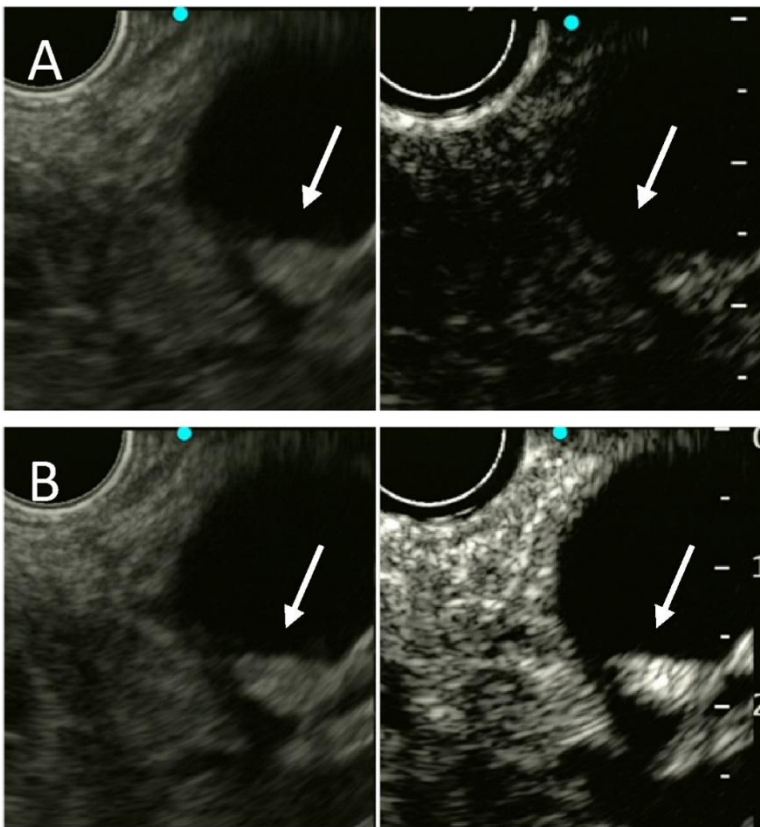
Endoscopic ultrasound detected a mural nodule. The original photo was downloaded on 17.04.2024 [76].
